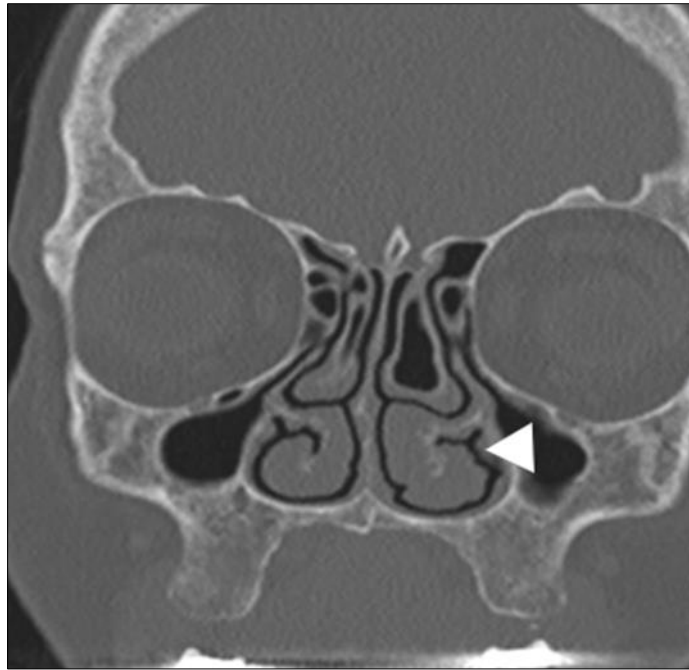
Coronal CT section showing left sided serrated inferior turbinate (White arrow head)
